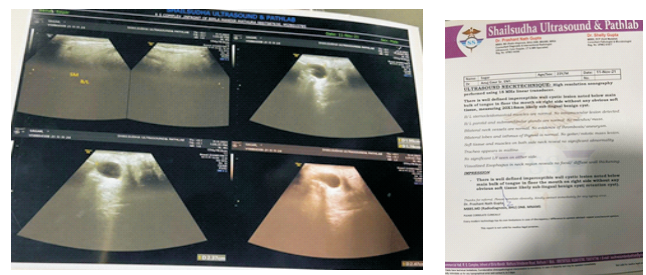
Ultrasound of sublingual gland
